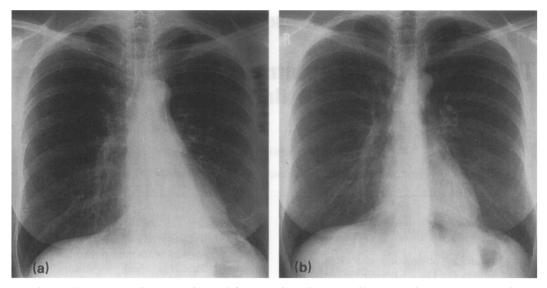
Chest radiograph of patient 1 showing (a) left lower lobe collapse and (b) re-expansion of the left lower lobe after treatment with ultrasonically nebulized normal saline.
